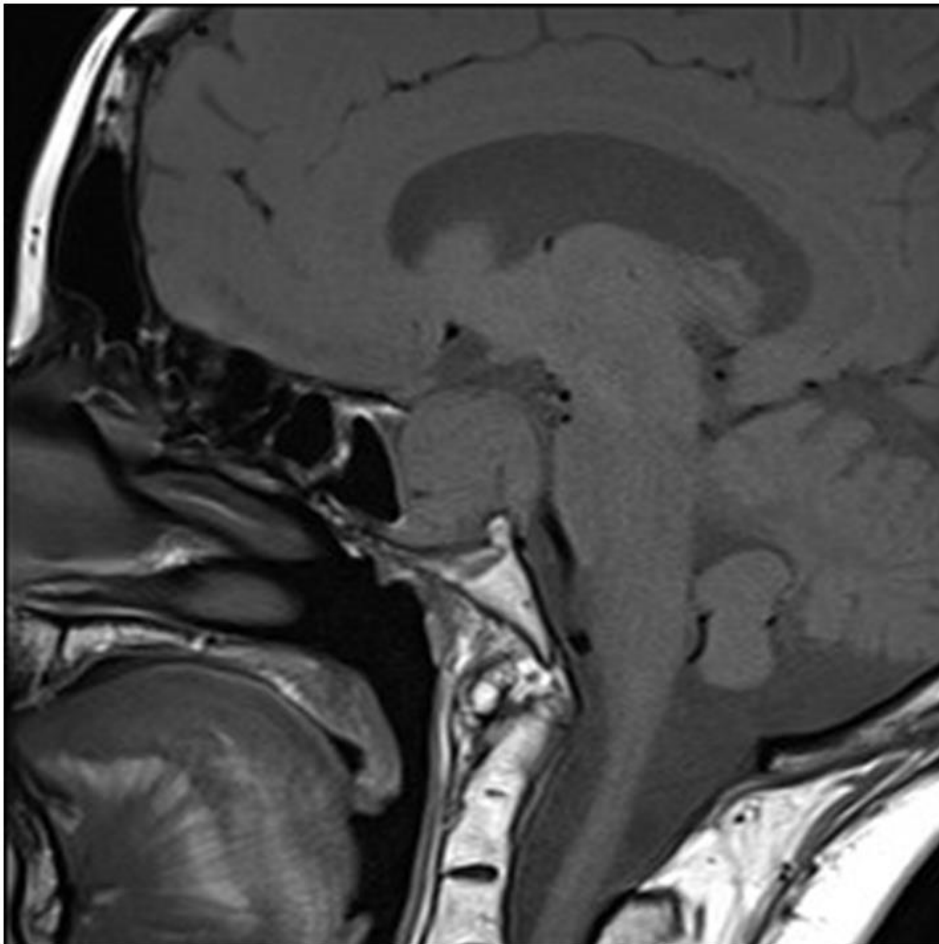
MRI brain demonstrated a 35x 24x 22mm pituitary fossa lesion with bilateral cavernous sinus invasion
